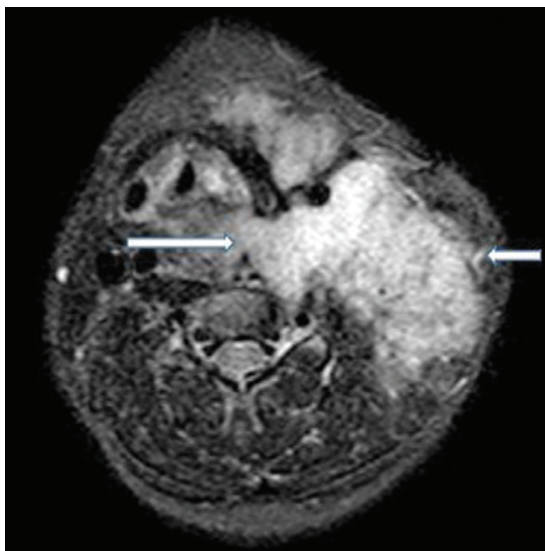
T2-weighted magnetic resonance image of the neck in axial view showed a hyperintense mass on the left side of the neck, extending to pre-laryngeal and prevertebral spaces (*arrows*).
